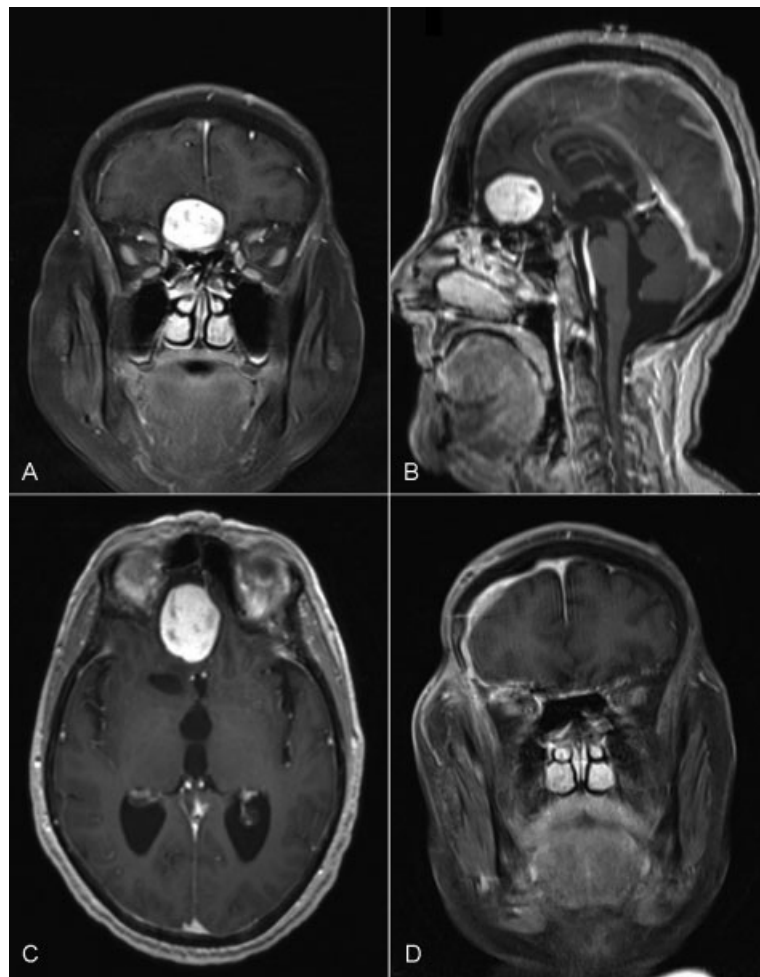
Coronal (A), sagittal (B), and axial (C) T1-weighted, gadolinium-enhanced, brain MR image demonstrating a well-circumscribed, homogeneously enhancing, extra-axial, anterior cranial fossa lesion eroding the ethmoid bone. Coronal (D) T1-weighted, gadolinium-enhanced, brain MR image showing gross total resection of the tumor.
